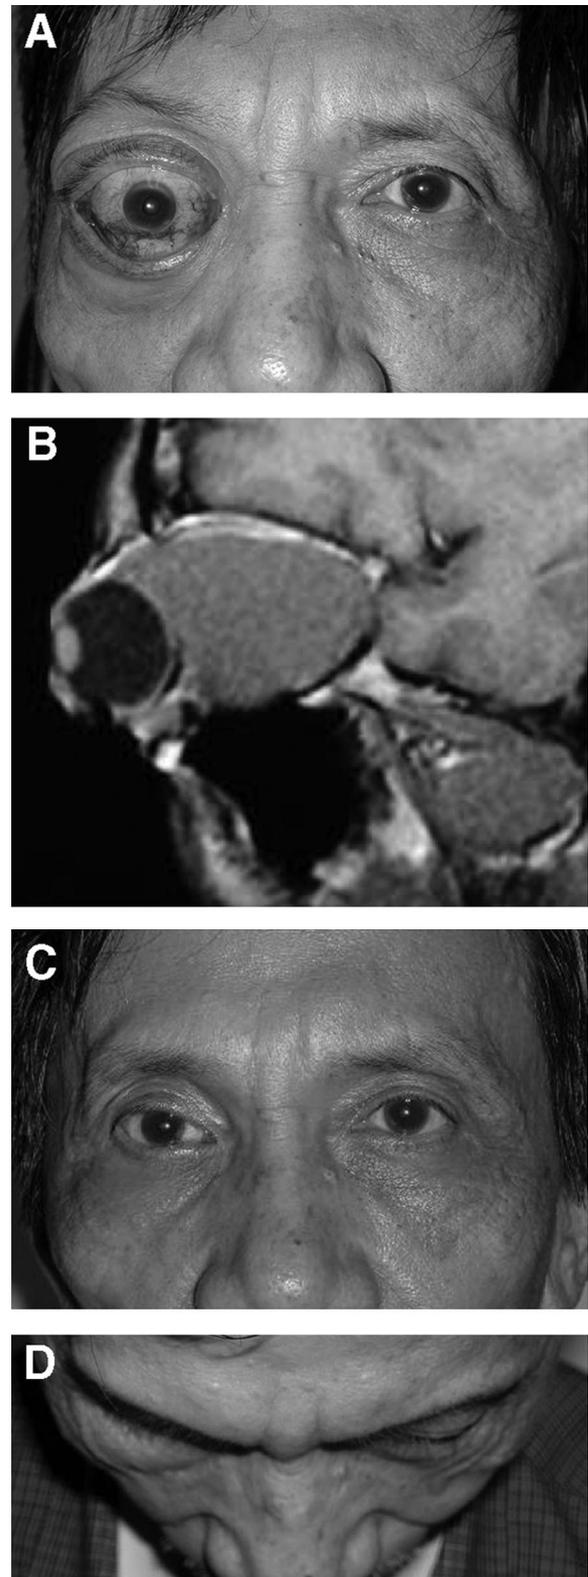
A, Preoperative proptosis in the right eye. B, Axial CT shows a large intraconal cavernous hemangioma. C, Postoperative appearance with right exotropia and enophthalmos.
